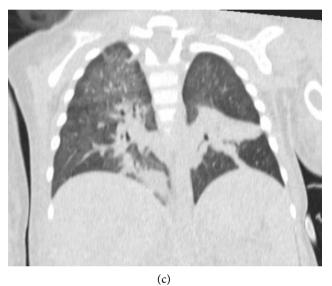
Chest CT scan images: (a) Bilateral ground glass opacities and consolidations—axial plane; (b) Bilateral ground glass opacities and consolidations—sagittal plane; (c) Bilateral ground glass opacities and consolidations—coronal plane.
